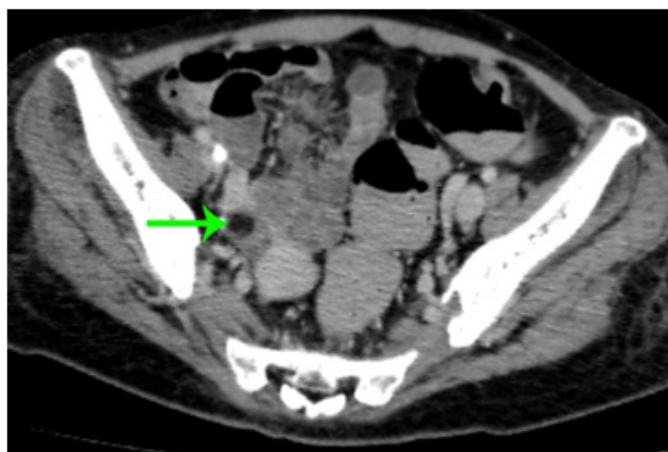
Pelvic CT scan revealed right ovary teratoma(Arrow).
